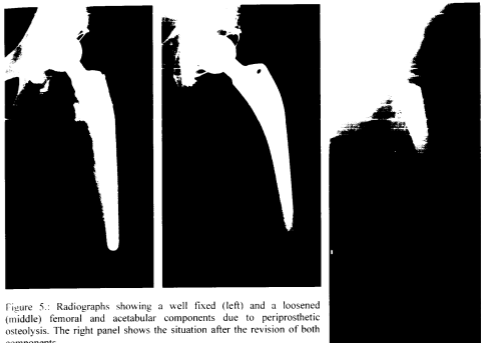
Radiographs showing a well fixed (left) and a loosened (middle) femoral and acetabular components due to periprosthetic osteolysis. The right panel shows the situation after the revision of both components.
